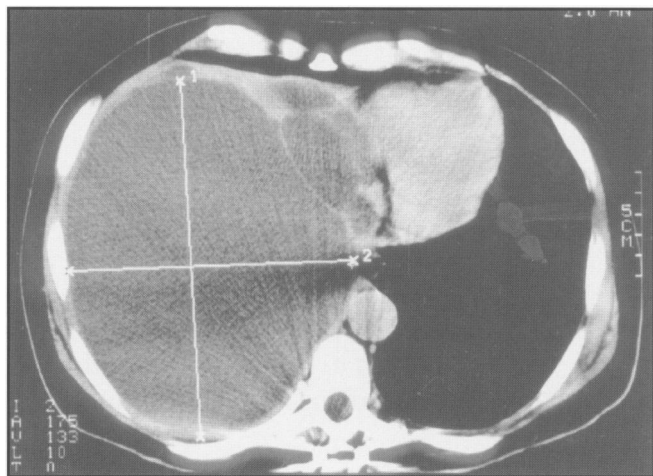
CT scan demonstrating multiple liver cysts in a patient with PCLD and one very large cyst. Surgical deroofing/cyst excision in such a patient achieves a very significant reduction on the mass effect and good symptom relief.
